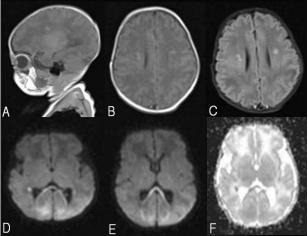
TIWI – parasagittal (A), axial(B), FLAIR(C), DWI(D, E) and ADC (F) – showing restricted diffusion in splenium with low ADC values. Punctate haemorrhage in bilateral periventricular white matter appear hyperintense on T1WI and FLAIR with restricted diffusion on DWI
